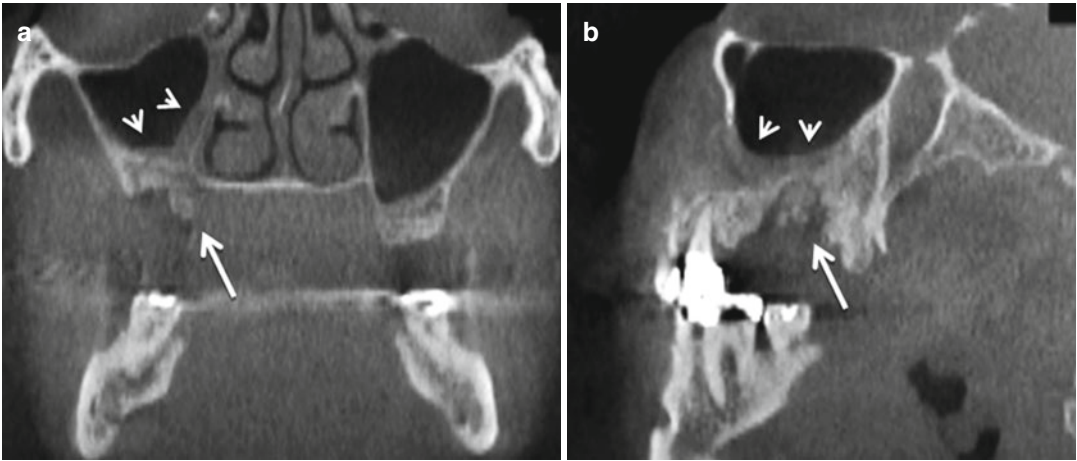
A 73-year-old male clinically presenting with signs of sinusitis and exposed bone in the right posterior maxilla. (a) Coronal and (b) sagittal sections derived from CBCT
